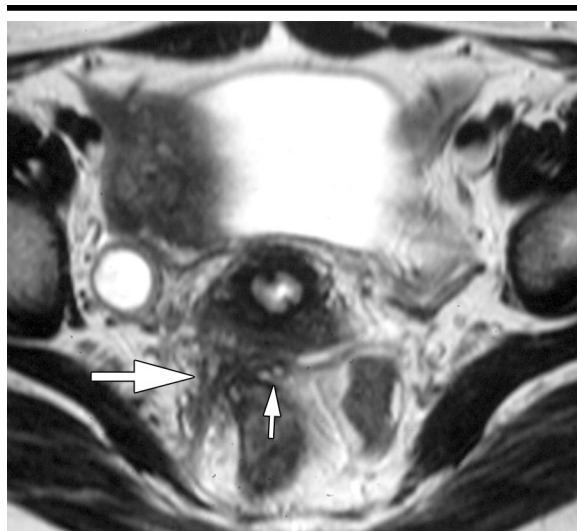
Transverse T2-weighted fast spin-echo MR image (4,500/128) demonstrates irregular solid area with signal intensity close to that of pelvic muscle (thick arrow) at patient's right; area contains foci of high signal intensity (thin arrow) between lateral part of rectovaginal septum and rectal wall. True-positive diagnosis of rectovaginal involvement with endometriosis was determined at MR imaging.
